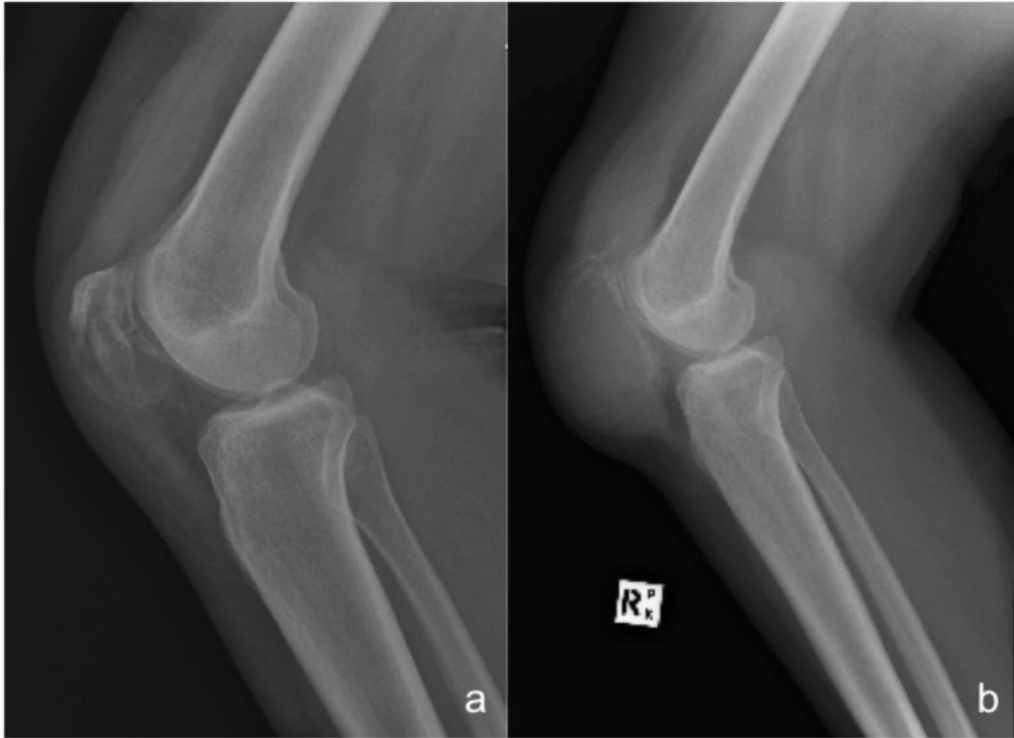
Lateral radiographs of the right knee obtained at: (a) initial presentation; and (b) 7 months after injury.
